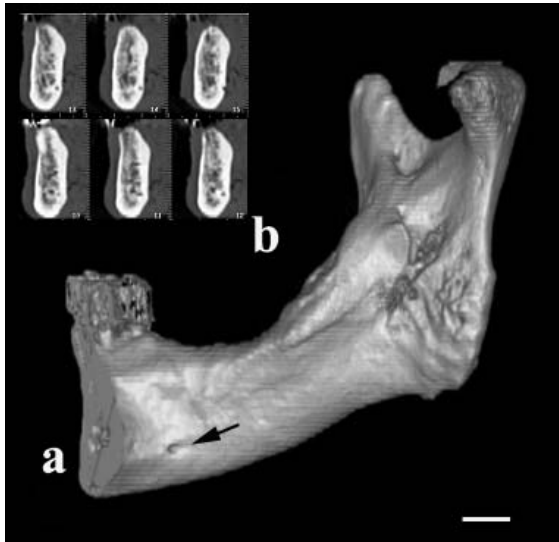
Three-dimensional reconstruction of the right half of the mandible. (a) The lingual foramen (arrow) was found near the basal region on the internal aspect of the mandible. (b) The lingual canal communicated with the inferior canal from reconstruction of continuous 6 slices of CT images. Bar = 1 cm
